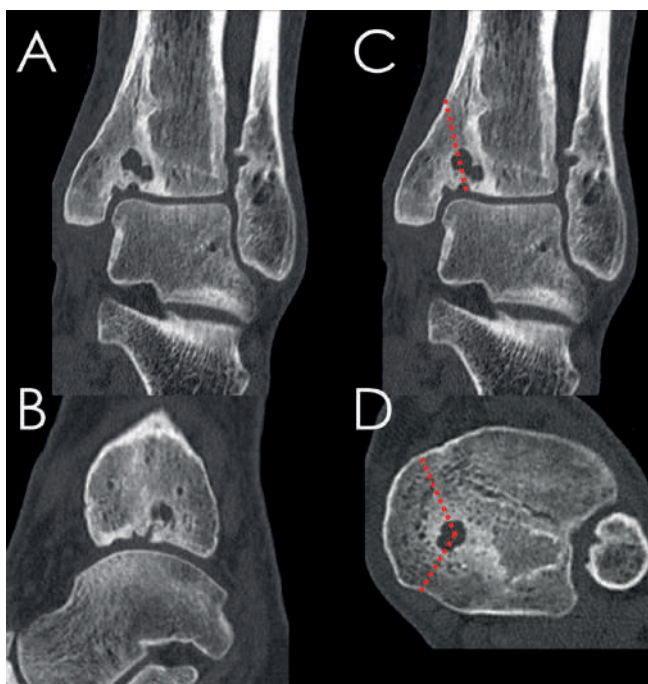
Preoperative coronal (A), sagittal (B), and axial (D) CT-scan of case 1. The case concerns a 40-year-old male, presenting with pain in activities of daily living 1 year after open-reduction and internal fixation for a closed bimalleolar ankle luxation fracture. Physical examination showed pain upon palpation of the OLTP and a similar range of motion to the contralateral side. CT-scan showed a large medial OLTP with large cyst formation. PET-CT and infectious blood lab results showed no signs of an active infection. The osteotomy is shown with a red-dotted line in a chevron configuration in C and D.
